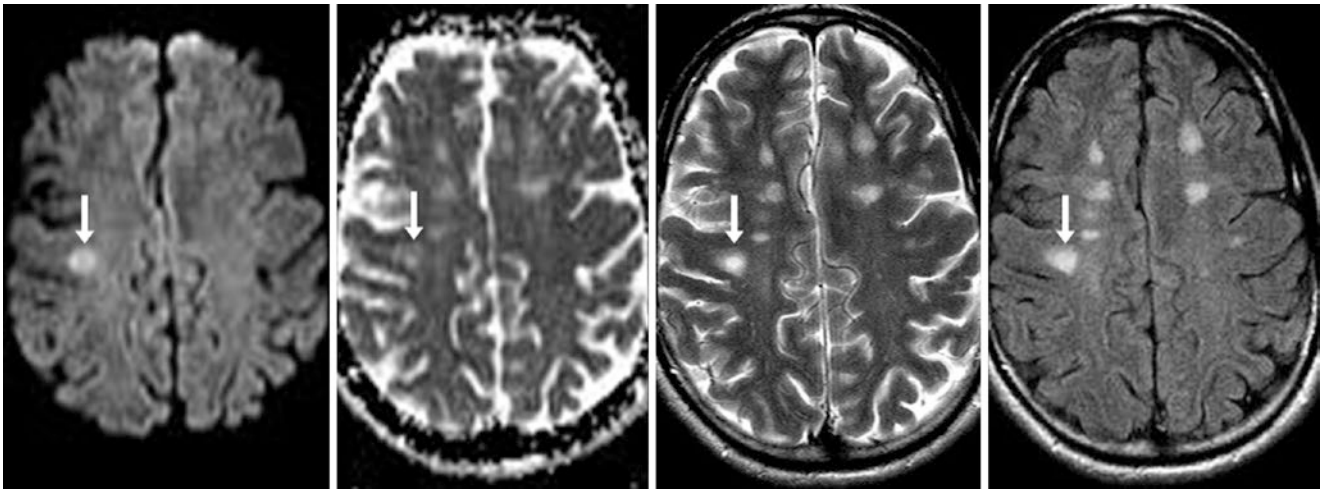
In a 34-year-old with MS, a 1.5 T MRI demonstrates a right frontal focus of hyperintense signal (*arrows*) on DWI (*left*) from MS, representing T2 shine-through, based on corresponding bright signal on
